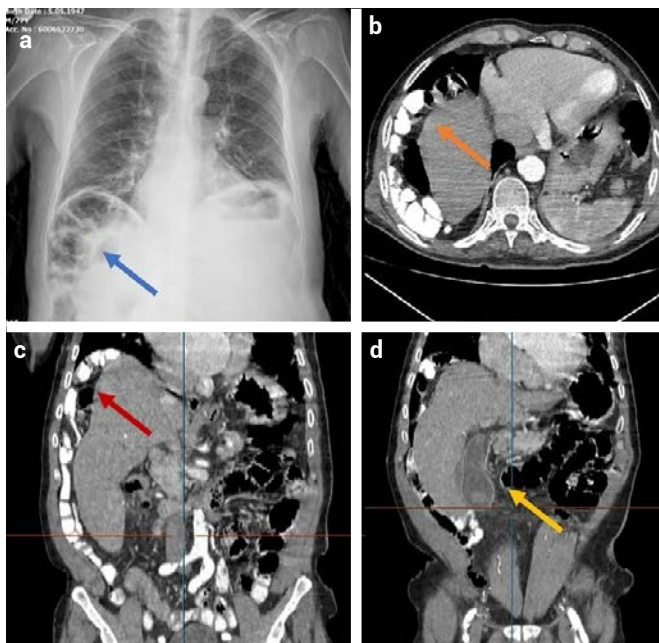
The preoperative images of an 84-year-old male patient with Chilaiditi syndrome (a) demonstrate a pneumoperitoneum-like appearance under the right diaphragm on a chest X-ray (blue arrow). Computed tomography (b and c) reveals the colon between the liver and diaphragm, while (d) shows the gallbladder below the level of the umbilicus.
